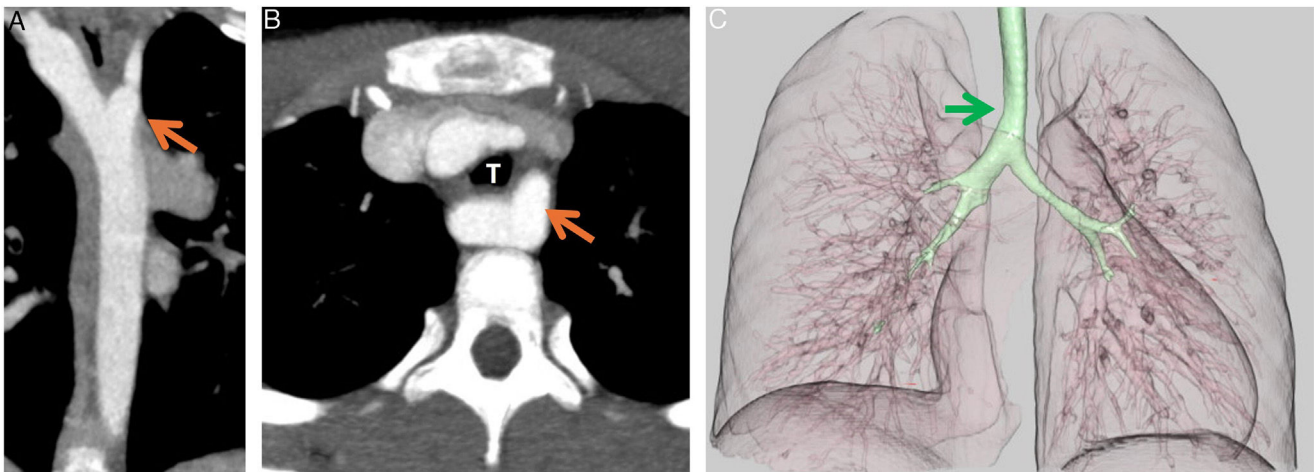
(A) Coronal CT image (B) Axial CT image showing the Kommerell diverticulum (orange arrow) in relation to the trachea (T). (C) 3D reconstruction of the tracheobronchial tree showing the compression of the trachea by the LSA (green arrow).
